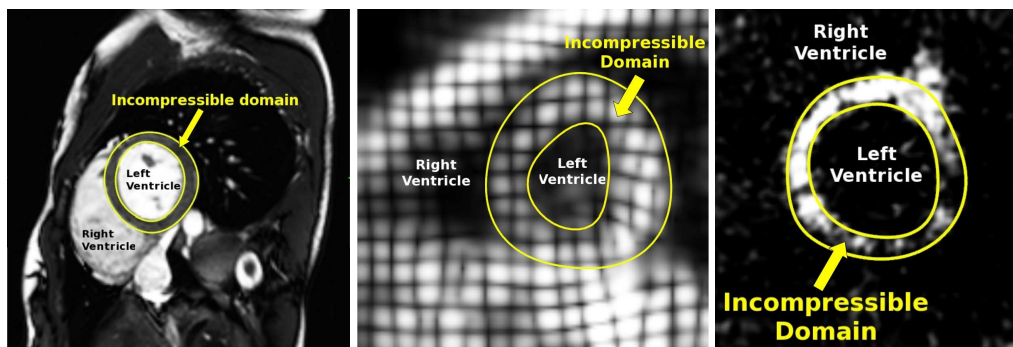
The incompressibility domain shown on a cine-MR image (left), tagged-MR image (center) and echocardiography image (right). This domain defines where the incompressibility constraint is enforced in the registration algorithm.
